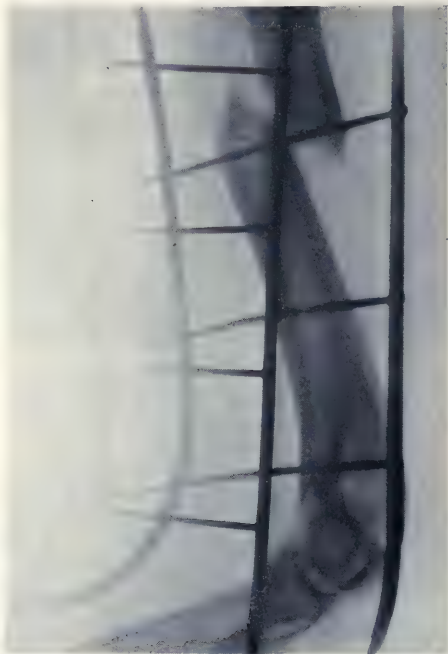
x-Ray of arm as it was found when patient entered the hospital October 10, 1918 (Case III).
